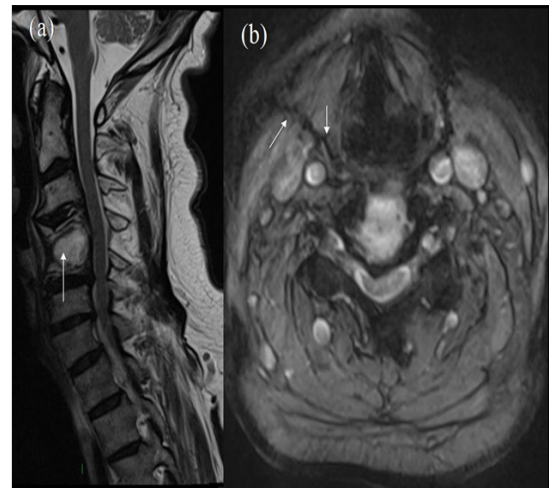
Post operative MRI. (a) T2 sagittal images show the "empty cavity" (white arrow) with otherwise stable appearance of the surrounding bones. (b) T2 gradient echo axial shows the healed sinus tract (white arrows).
